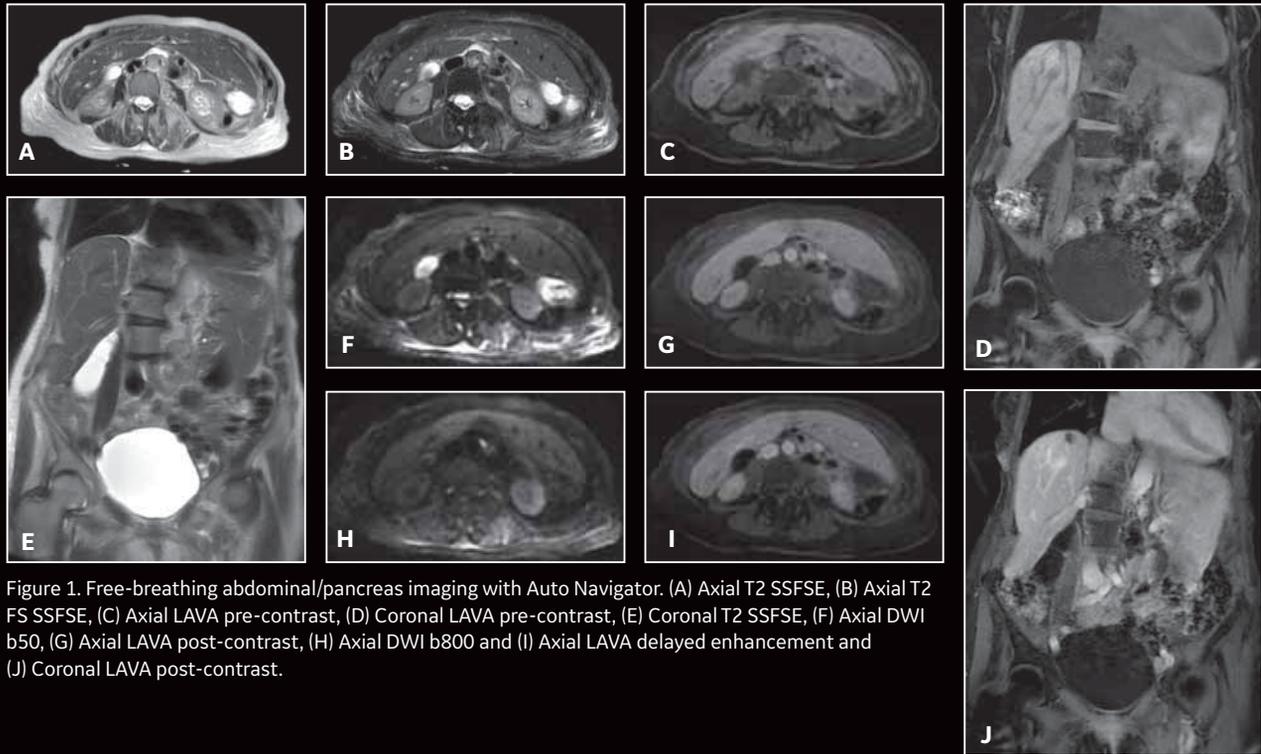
Free-breathing abdominal/pancreas imaging with Auto Navigator. (A) Axial T2 SSFSE, (B) Axial T2 FS SSFSE, (C) Axial LAVA pre-contrast, (D) Coronal LAVA pre-contrast, (E) Coronal T2 SSFSE, (F) Axial DWI b50, (G) Axial LAVA post-contrast, (H) Axial DWI b800 and (I) Axial LAVA delayed enhancement and (J) Coronal LAVA post-contrast.
